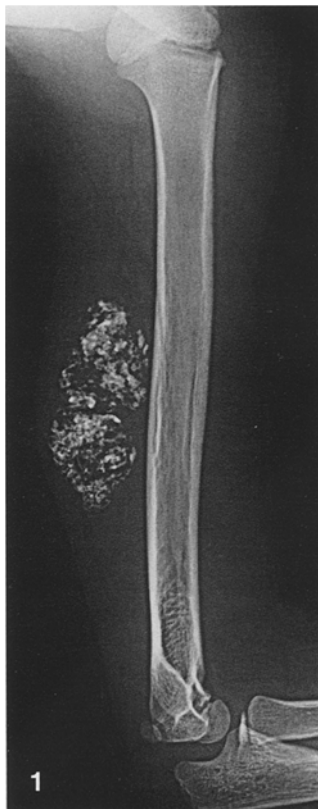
Plain X-ray of the left arm shows a posterolateral soft tissue tumor with numerous "cornflake" calcifications. The adjacent bone is intact, without periosteal reaction
